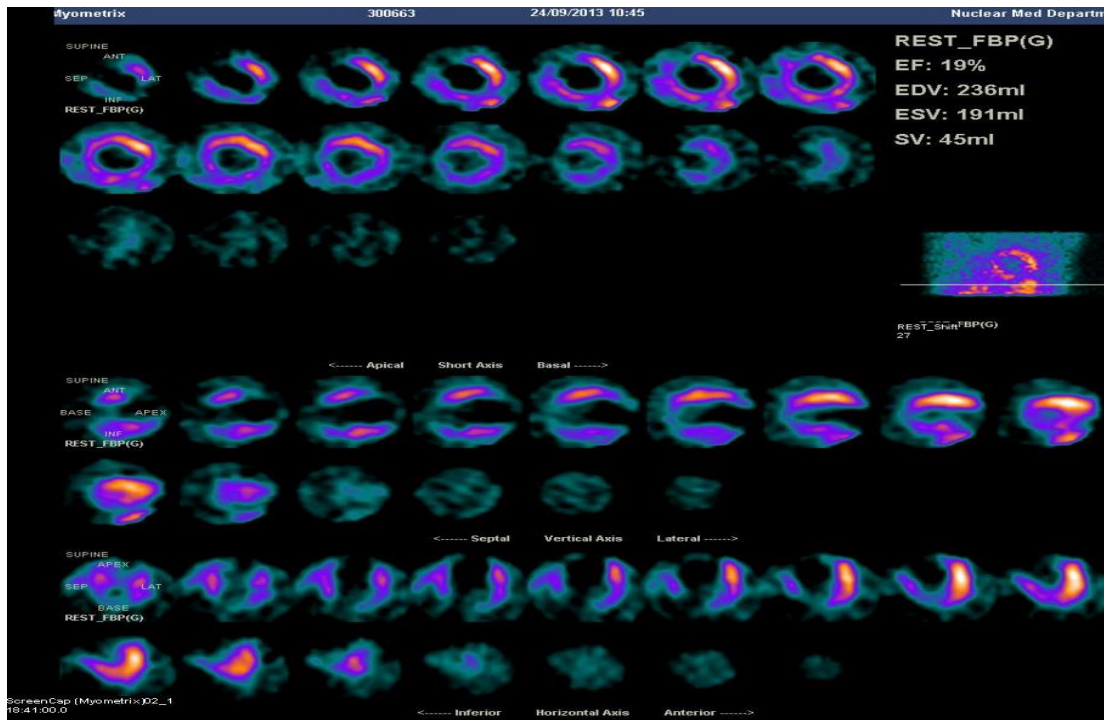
The gated SPECT ^{99m}T -tetrofosmin viability study images show marked reduced myocardial thickening and aknetic wall motion at the apex, anterior apical, anteroseptal mid and inferior mid segments.
